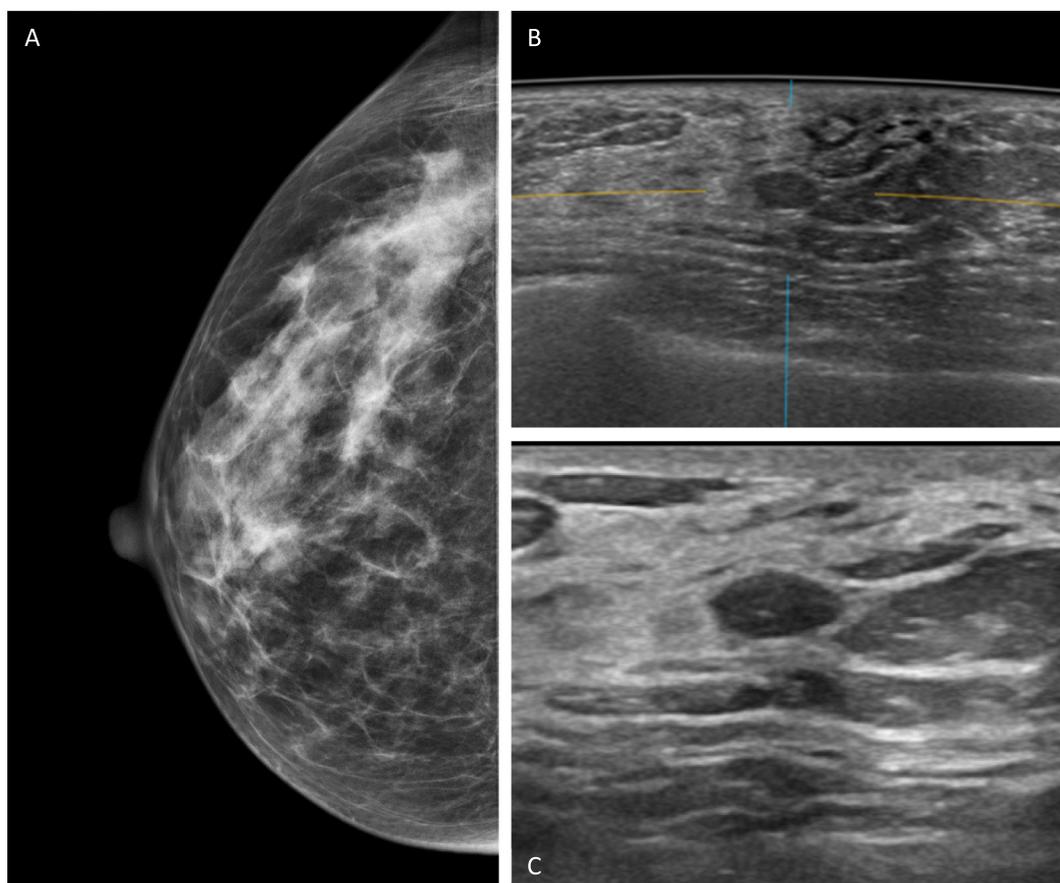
ABUS-only finding recalled with probably benign final assessment (patient 74). A) FFDM craniocaudal view of the right breast. The breast is heterogeneously dense. There are no suspicious masses or calcifications. B) ABUS of the right breast showed an oval hypoechoic mass at 7:00. C) Targeted ultrasound of the right breast at 7:00 showed an oval circumscribed solid mass, likely a fibroadenoma. BI-RADS 3 final assessment was issued but patient elected to undergo biopsy. Pathology revealed a fibroadenoma.
